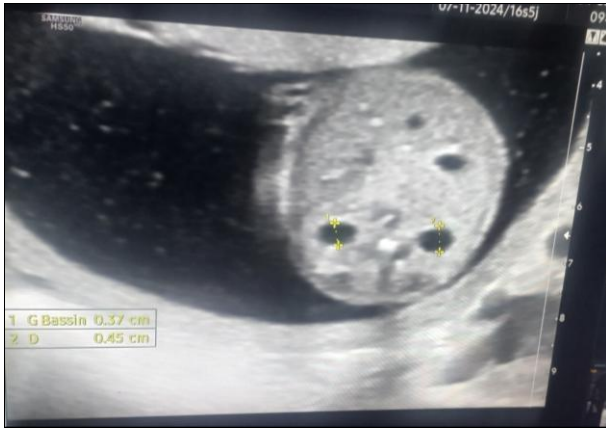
Prenatal ultrasound showing bilateral pelvic dilatation (pyelectasis) with preserved corticomedullary differentiation
